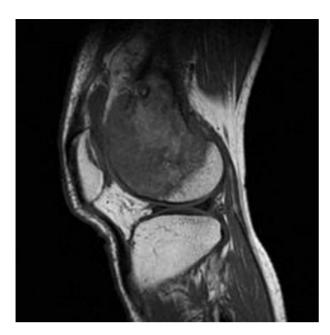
Knee magnetic resonance image (MRI) revealed a 7.6×5.9 cm sized cauliflower shaped signal intensity change of the bone marrow at the left distal femur. An anterolateral cortical break is noted and the mass was extended to the prefemoral space.
